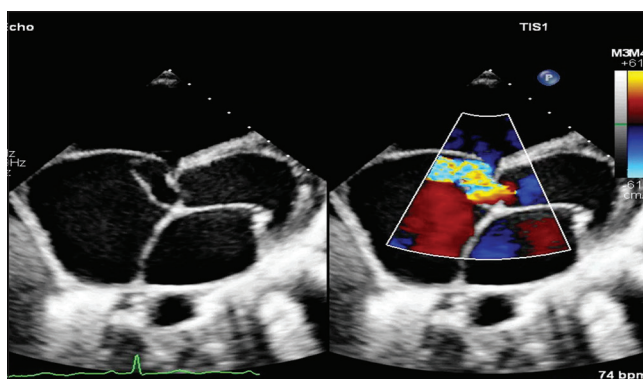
Modified parasternal short-axis echocardiographic image showing aneurysm of sinus of Valsalva arising from the noncoronary cusp and protruding into right atrium in the form of a wind-sock (arrow). Rupture at the tip is appreciated (arrowhead) leading to continuous turbulent flow into right atrium.
